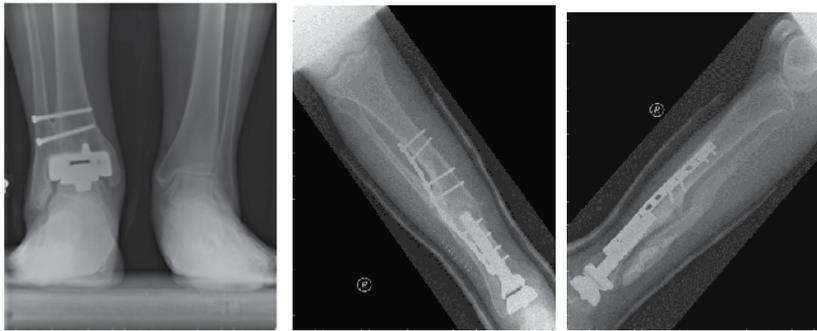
Radiographic images of two currently used fixed bearing total ankle arthroplasty designs. The left image is Agility while the right two images are Inbone.
